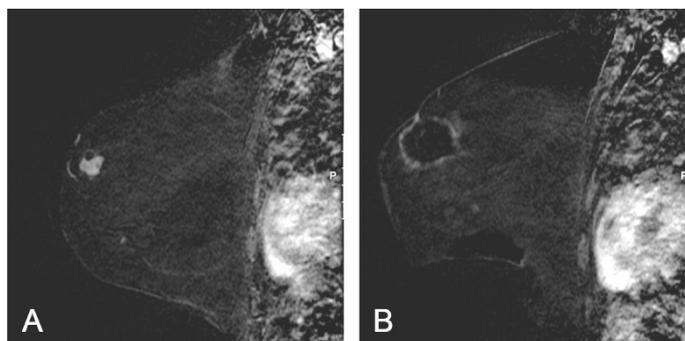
MR images of patient number 3 in Paper V Pre-RFA (A) and 1 month post-ablation (B).
